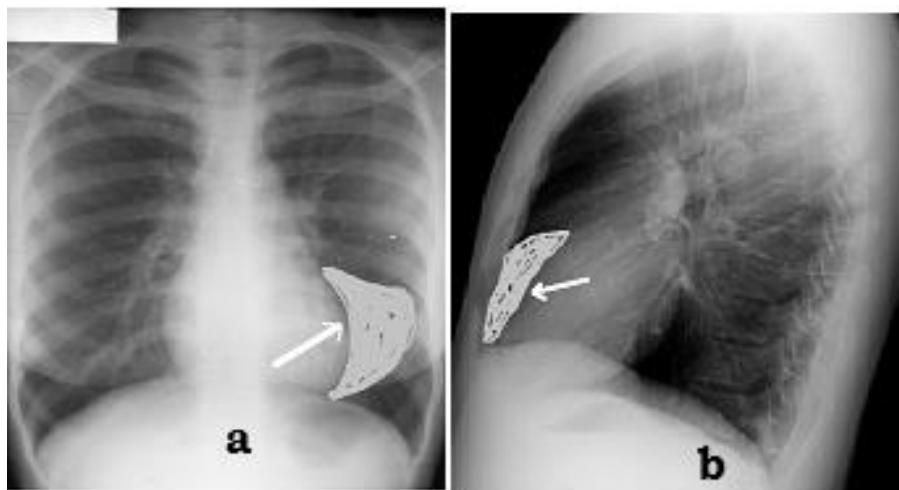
Chest radiographs showing how the right ventricle enlarges.
